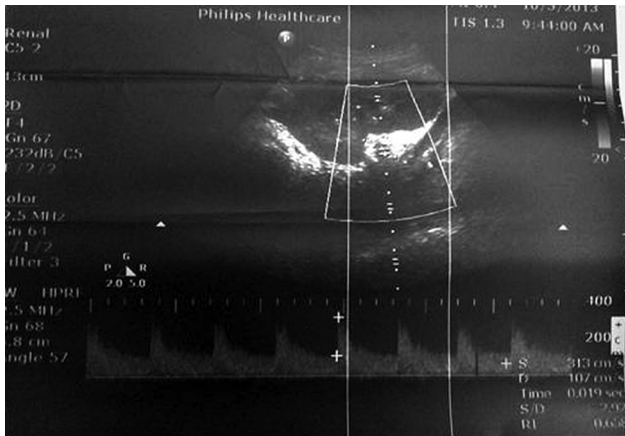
Doppler USG revealed narrowing of the renal artery with a maximum PSV of 320 cm/s at the site of narrowing.
